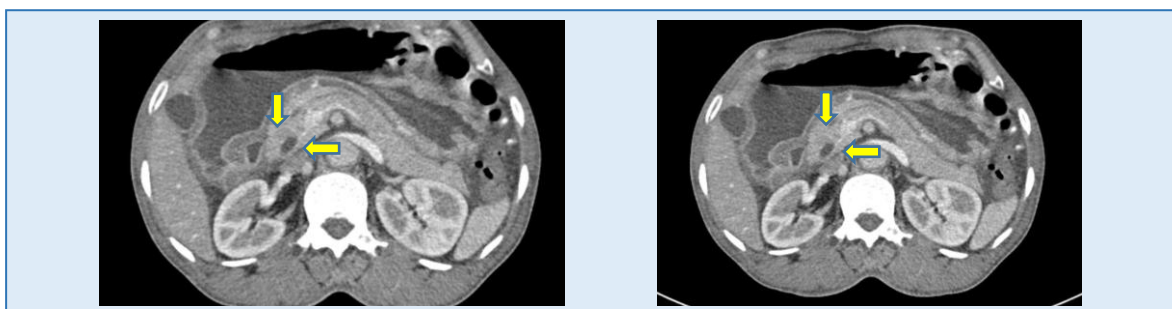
Contrast-enhanced computed tomography (CECT) showing dilated stomach and duodenal bulb, pancreatic tissue surrounding the left lateral wall of the duodenum 2nd part with narrowing duodenum (crocodile jaw appearance)
